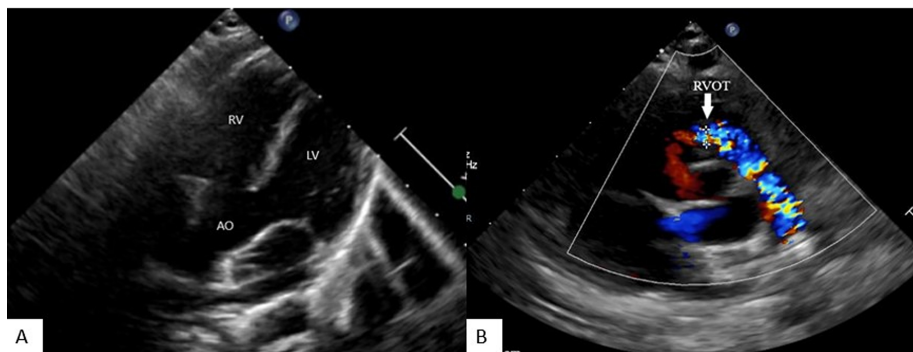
(A, B). Long axis and modified short axis transthoracic echocardiography showing posterior malalignment ventricular septal defect and RV outflow tract. LV, left ventricle; RV, right ventricle; AO, aorta; RVOT, right ventricle outflow tract.
